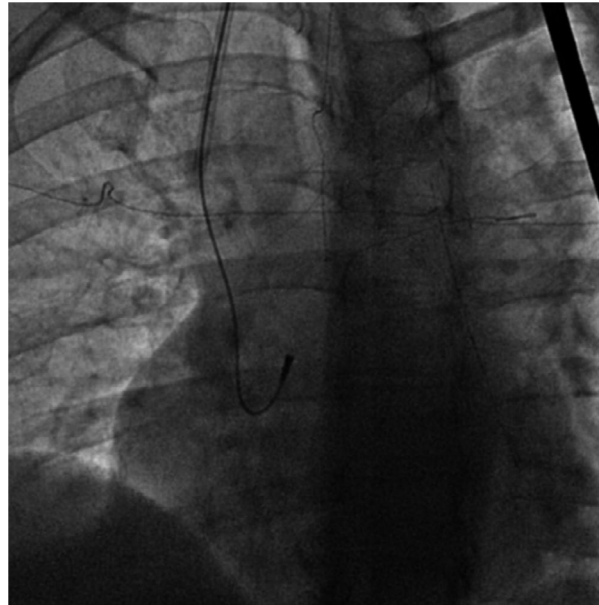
Placement of an internal fiducial marker to improve the accuracy of SBRT treatment. This fluoroscopic image shows the position of the fiducial marker placed via right internal jugular vein access, and affixed to the right side of the interatrial septum, in close proximity to the LA target. Compensation for cardiorespiratory motion during SBRT is achieved by the external beam delivery system through tracking of fiducial movement using planar x-ray imaging [30].
